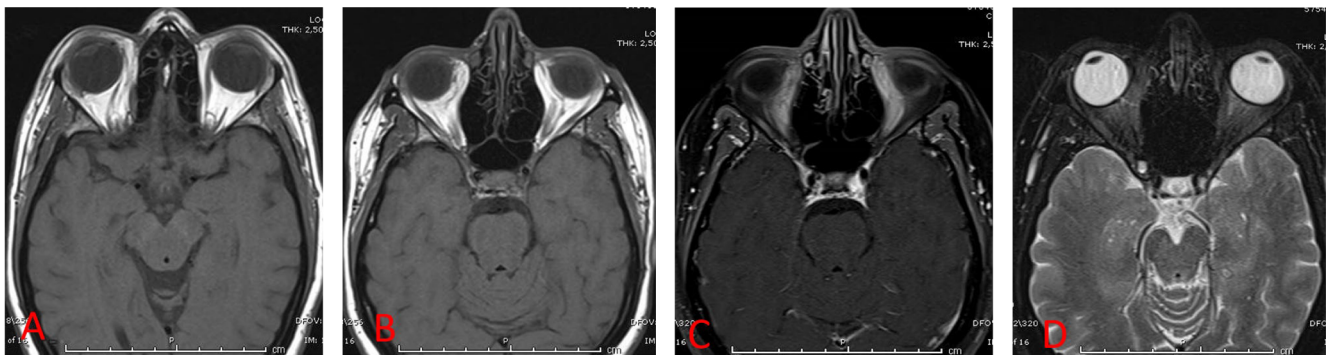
T1-weighted spin-eco (A and B), T2-weighted fat-saturated (A), and post-contrast T1-weighted (B) images from the orbital MR imaging showed no abnormalities. Of note, there are no signs of ocular proptosis or superior ophthalmic vein dilatation.
